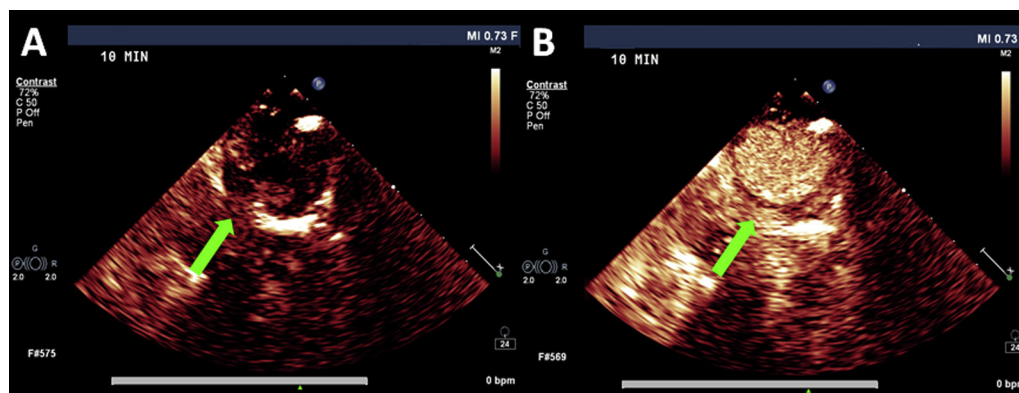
Low-mechanical index two-dimensional echocardiography of the left main pulmonary artery demonstrating microbubbles passing through the thrombotic occlusion. Images are acquired immediately after (A) and 2 sec after microbubble destruction by high-mechanical index impulses (B), where the presence of microbubbles can be detected (arrows).
